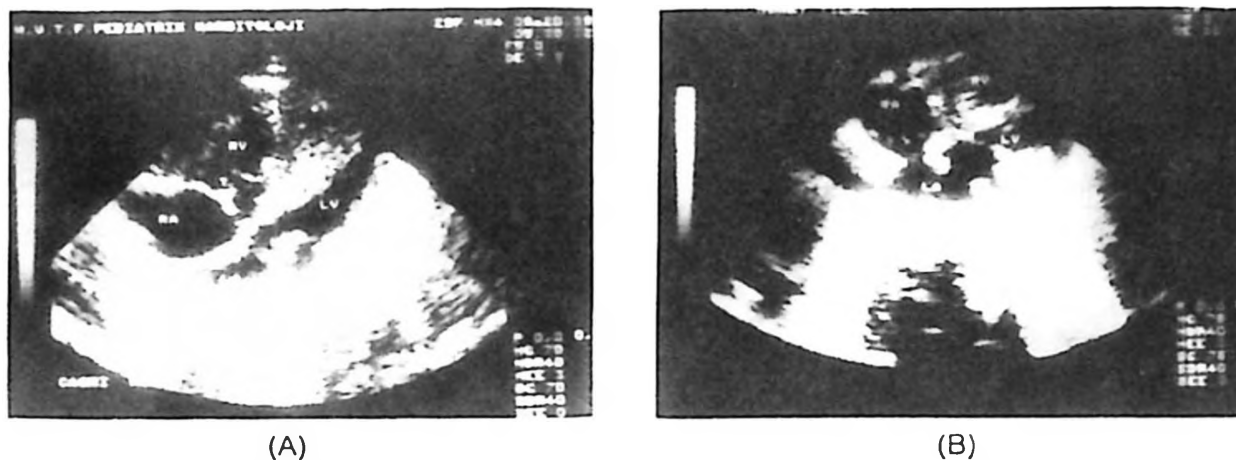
Two-dimensional echocardiogram demonstrating an intact inter-atrial septum (A). After the blade atrial septostomy procedure, an adequate inter-atrial opening was obtained (B). LA: left atrium, LV: left ventricle, M: mitral valve, RA: right atrium, RV: right ventricle, T: tricuspid valve, Arrow: interatrial opening.
